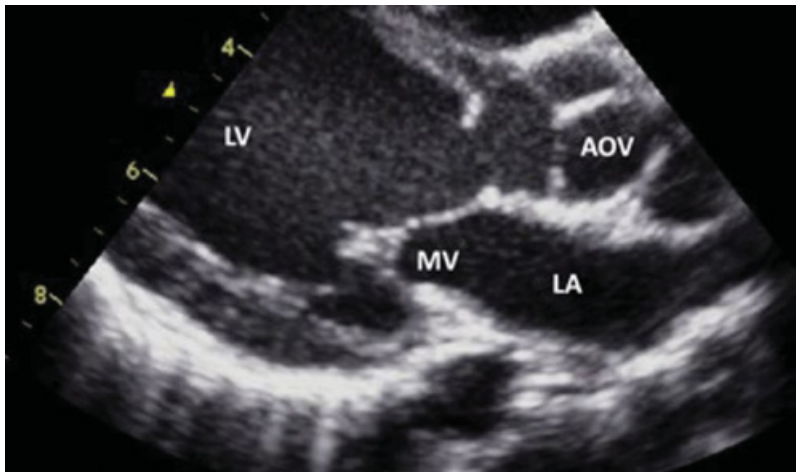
Parasternal long axis view of subvalvular aortic stenosis with fibromuscular ridge.
